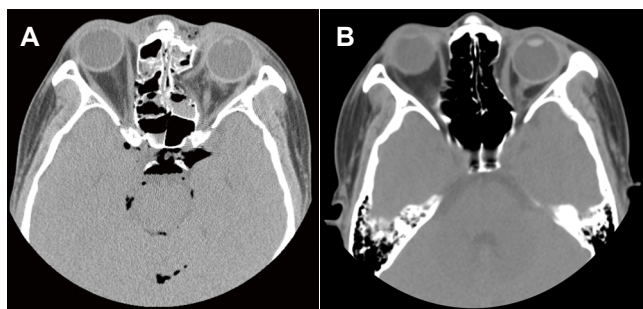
Axial computed tomography scans. (A) Fracture of the medial orbital wall and herniation of the soft tissue; (B) 190 days after CPS sheet insertion before secondary orbital floor reconstruction
